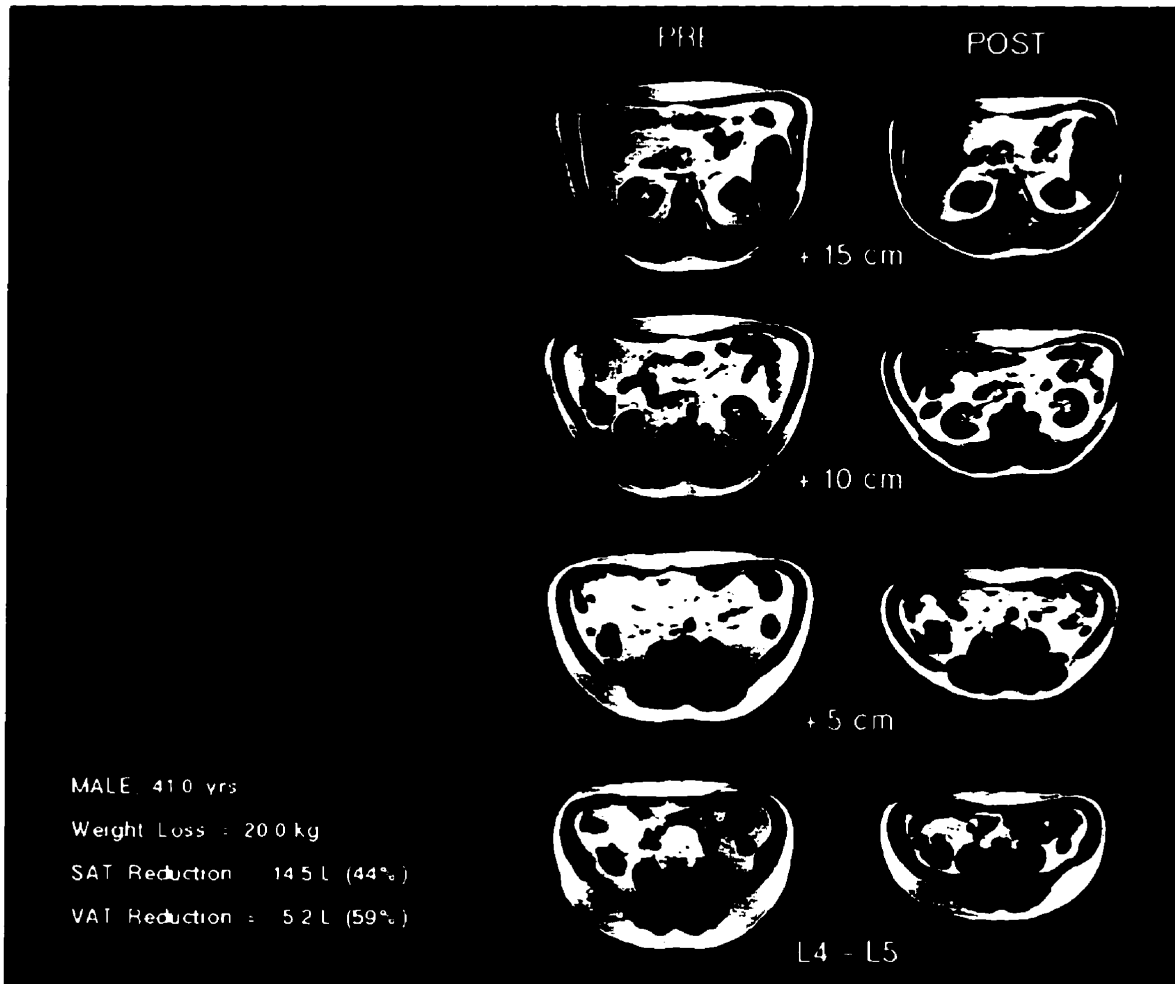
A typical example of the reductions observed for SAT and VAT for a series of MR images throughout the abdomen.
